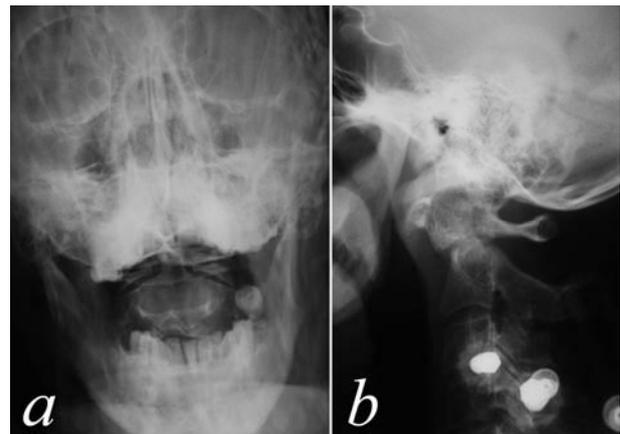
X-ray of type III dens fracture non-union 28 months postinjury before treatment. a – front view; c – lateral view
